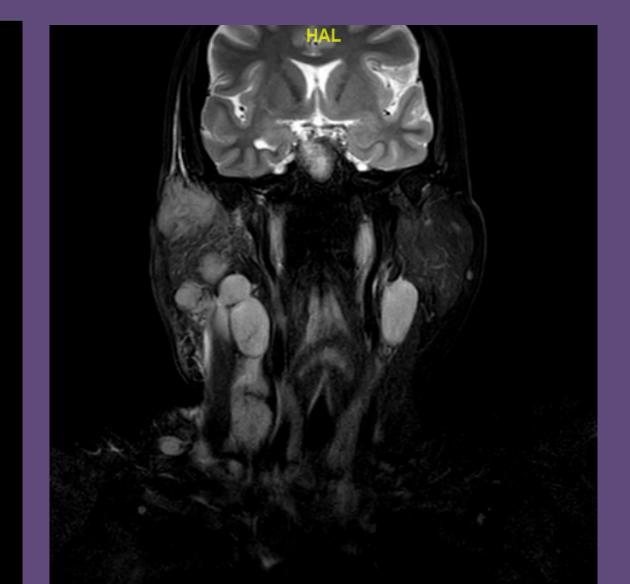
MRI Face and Neck with and without contrast 10/6/2022. Irregular enhancing mass centered about the right inferior concha with bulky head demonstrates central areas of and neck lymphadenopathy most consistent with metastatic nasopharyngeal carcinoma.
